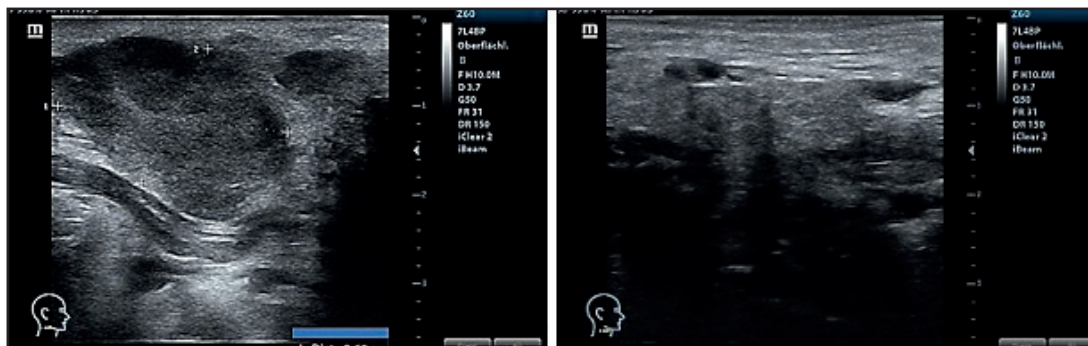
Sonography of the parotid-adjacent tumor before TMI treatment (left) and regression two months later after TMI treatment (right).
